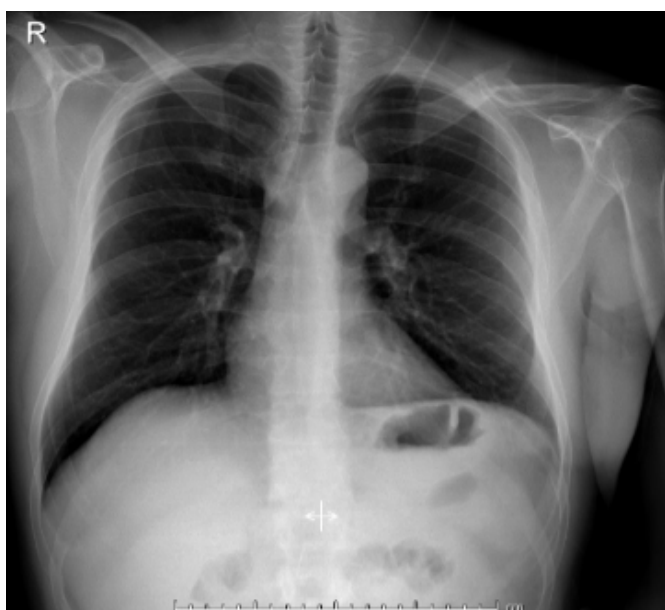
Preoperative and postoperative PA chest radiography.
